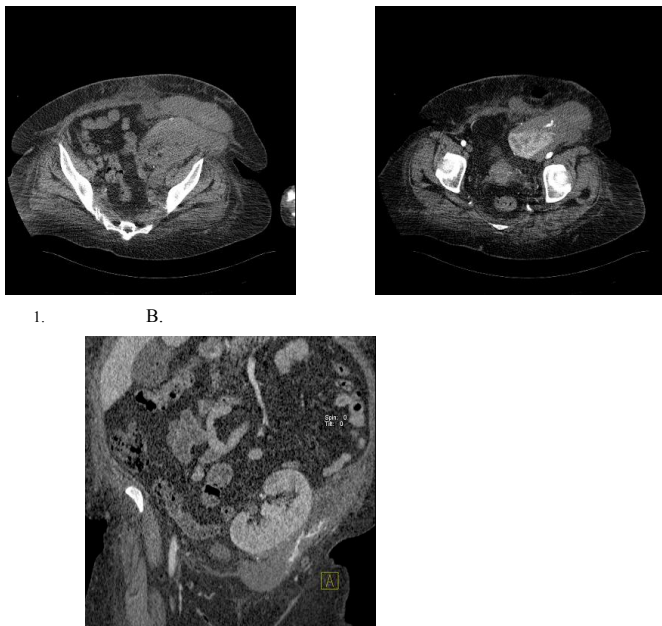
A-B-C: Abdominal CT revealed perirenal subcapsular hematoma (Figure A), defect and lacking contrast media in inferior pole of transplant kidney (Figure B). During operation, the surgeons detected three lacerations in the transplanted kidney (Figure C).
